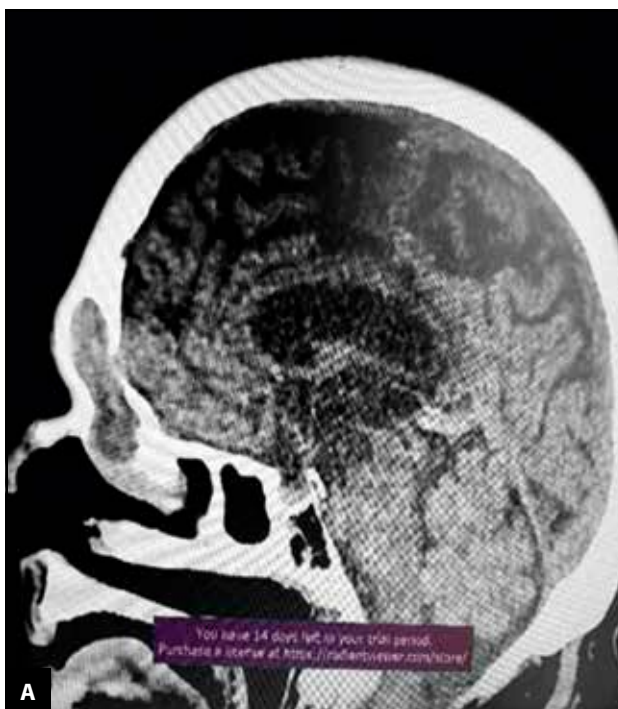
Crano-facial CT scan: A – sagittal slice showing a convex space-occupying opacity with thinned and eroded bone walls displacing adjacent structures with a homogeneous content; B – coronal slice showing a left-sided well-circumscribed soft tissue mass with lateral displacement of the orbit.
